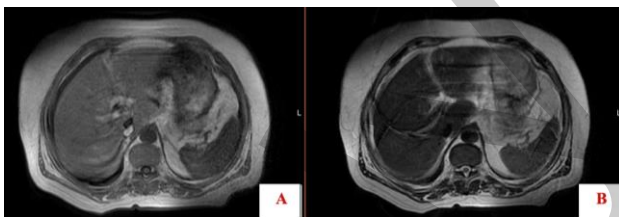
Magnetic resonance imaging reveals A) T1 in-phase and out-of-phase axial sequences, and B) T2 fast spin-echo axial sequences, with no evidence of splenic parenchymal metastasis
